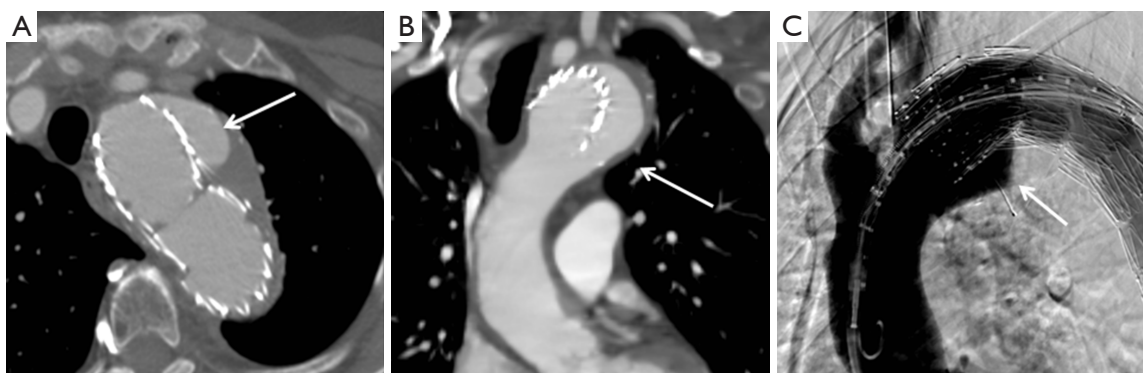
An 83-year-old female with type IA endoleak. (A) Axial CT angiogram image shows contrast material outside stent-graft but within aneurysm sac (arrow), indicating endoleak at the proximal attachment; (B) coronal reformatted CT image shows contrast material outside the graft (arrow); (C) digital subtraction angiography (DSA) demonstrating type IA endoleak (arrow).
